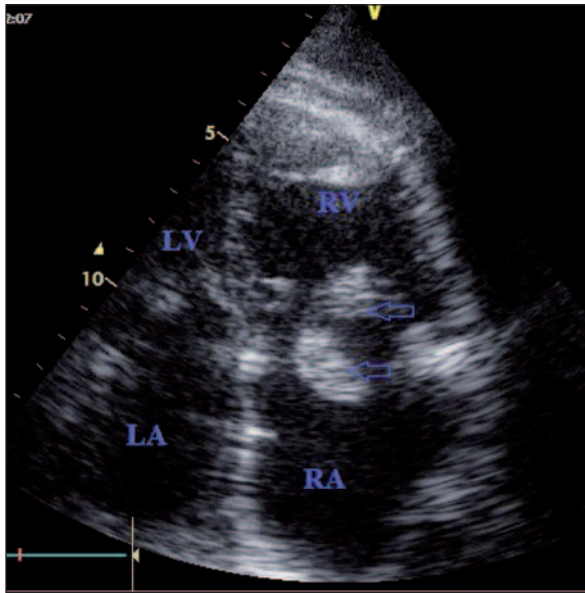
Right atrium (RA), right ventricle (RV), left atrium (LA) and left ventricle (LV), are seen in this apical four-chamber view. Thrombus is shown with arrows and extends to both RV and RA.
